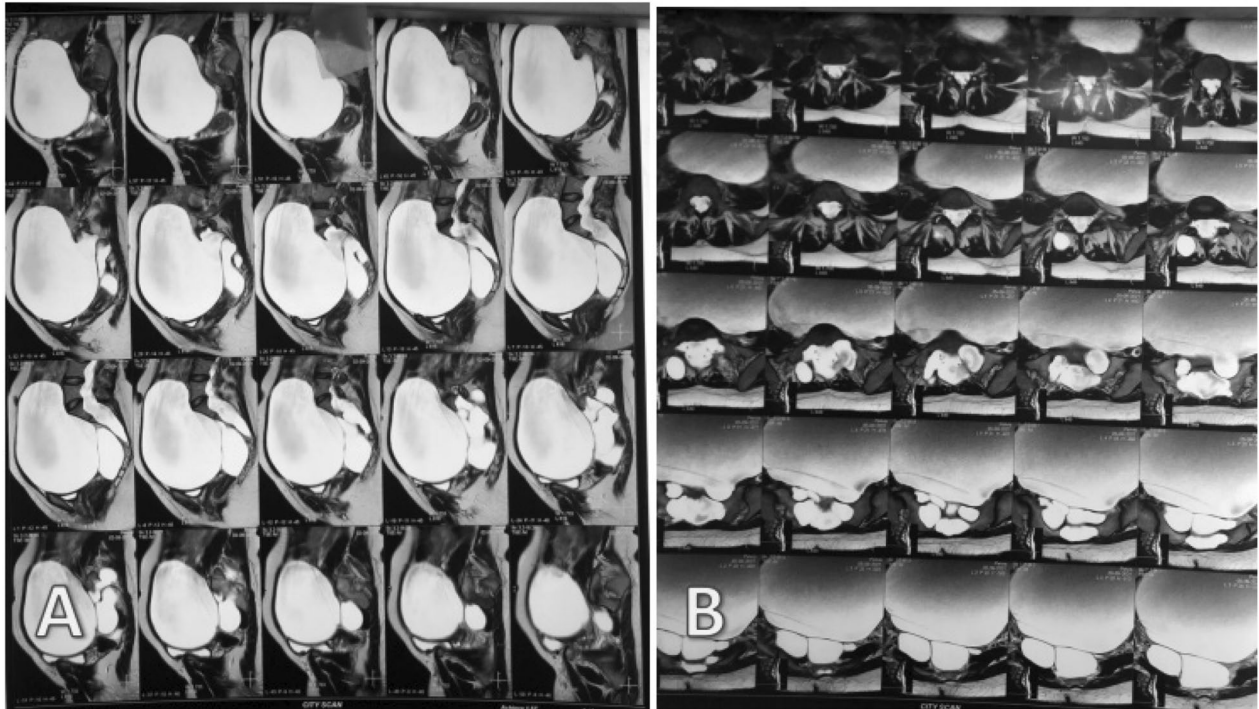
Preoperative sagittal (A) and axial (B) MRI T2WI of abdomen and pelvis showing a huge anterior sacral meningocele with multiple separations
